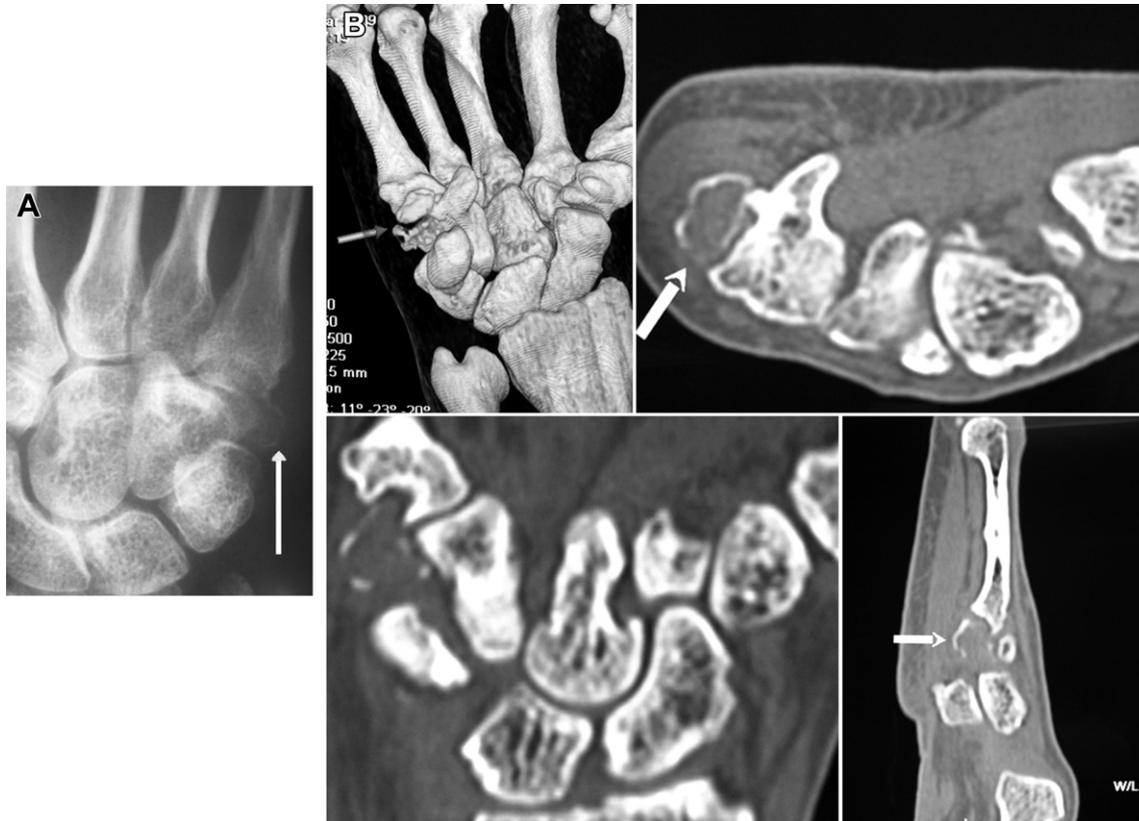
(A) The radiographs showed a bony mass ulnar to the base of the fifth metacarpal bone with erosion of surrounding bone; (B) computed tomography scan showing the lesion that indents and erodes into the base of the fifth metacarpal.
